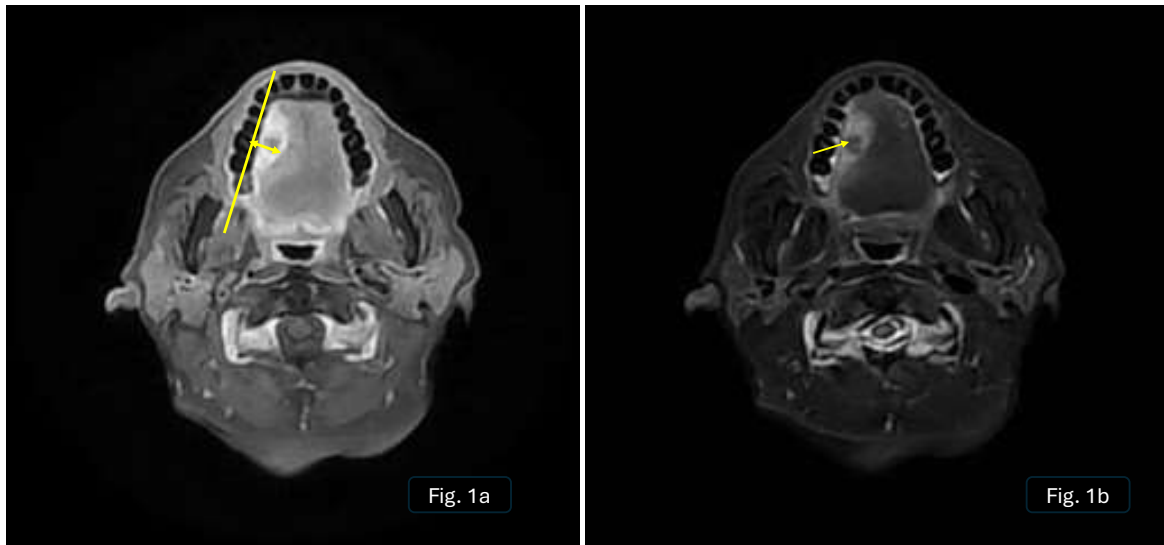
A 74-year-old female with oral ulcer on right lateral aspect of tongue underwent Mult sequential CE-MRI face and neck
